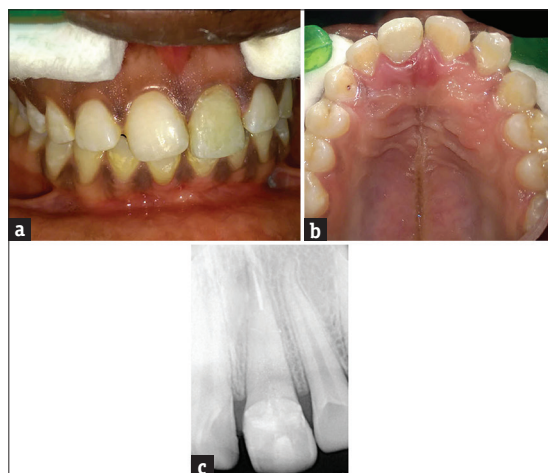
(a and b) Clinical images of follow-up after 1 year. (c) Follow-up radiograph
